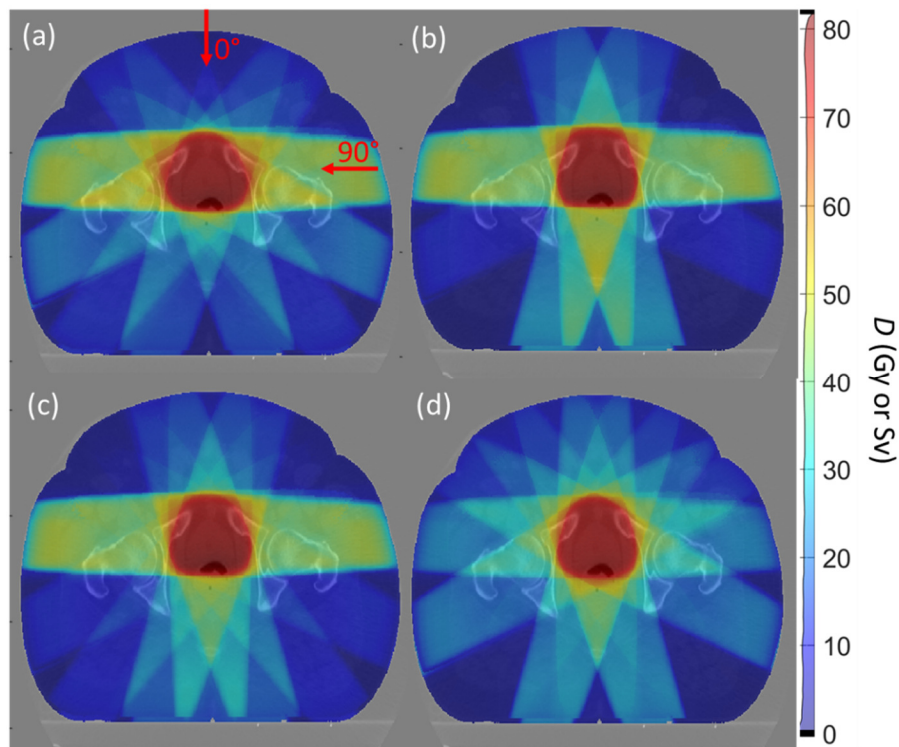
Representative example of unique treatment plans for one patient and one treatment modality. Absorbed dose is pictured as a color wash overlaid onto the isocentric slice of the patient computed tomography (CT) for (a) OORT based on late-risk calculated by the LNT model, (b) OORT based on the L-Exp10 late-risk model, (c) OORT based on L-Exp40, L-Plat10, and L-Plat40, and mechanistic late-risk models, and (d) DORT. Examples are shown for the 15-MV photon treatment plans for patient number five and are representative.
